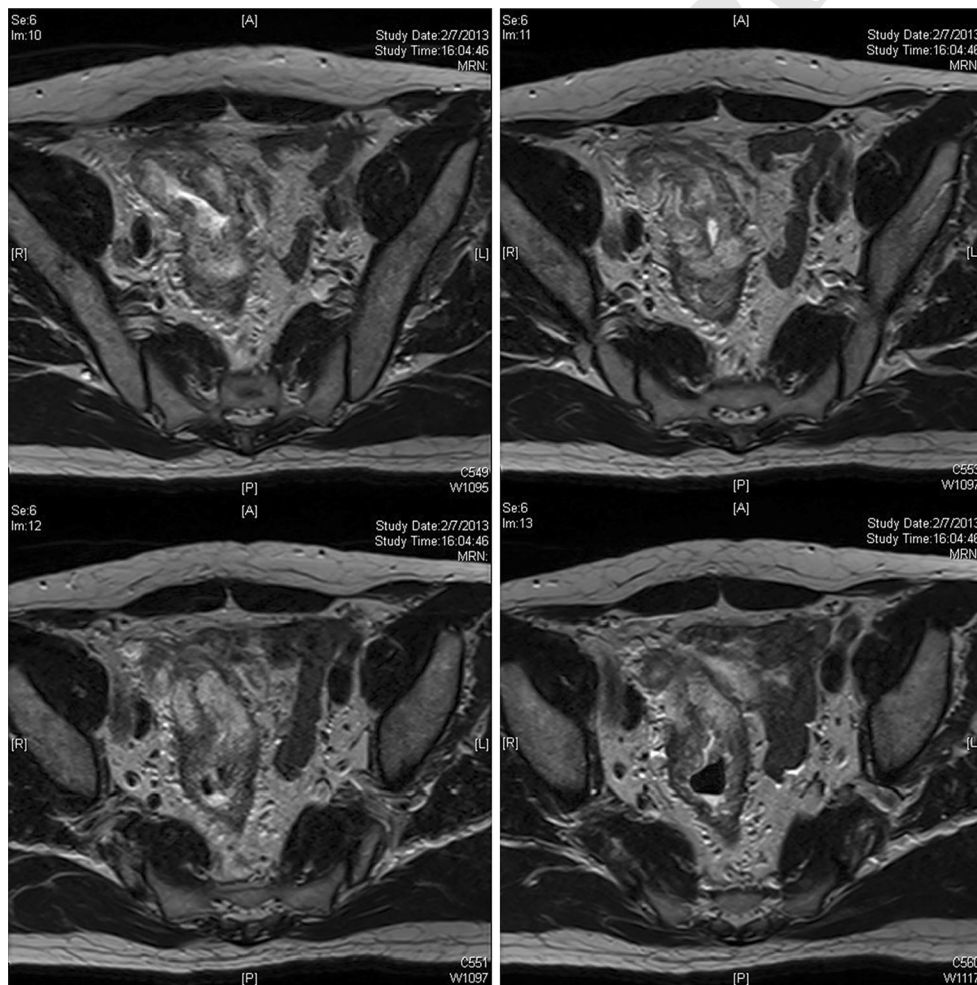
MRI showing an upper rectal tumour
